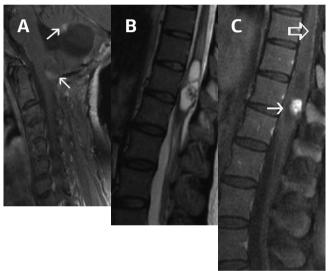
A 29-year-old female with multiple hemangioblastoma lesions in the spinal cord and cerebellum in von Hippel-Lindau (VHL) syndrome. Sagittal postcontrast T1- weighted images (A) show enhanced nodule posterior aspects of the cord and cerebellum (arrows). Sagittal T2-weighted (B) consistent with edema and a cystic mass. Sagittal postcontrast T1-weighted images (C) enhanced nodule (arrow) and open arrow show a hyperintense linear structure consistent with a vessel posterior to the cord.
